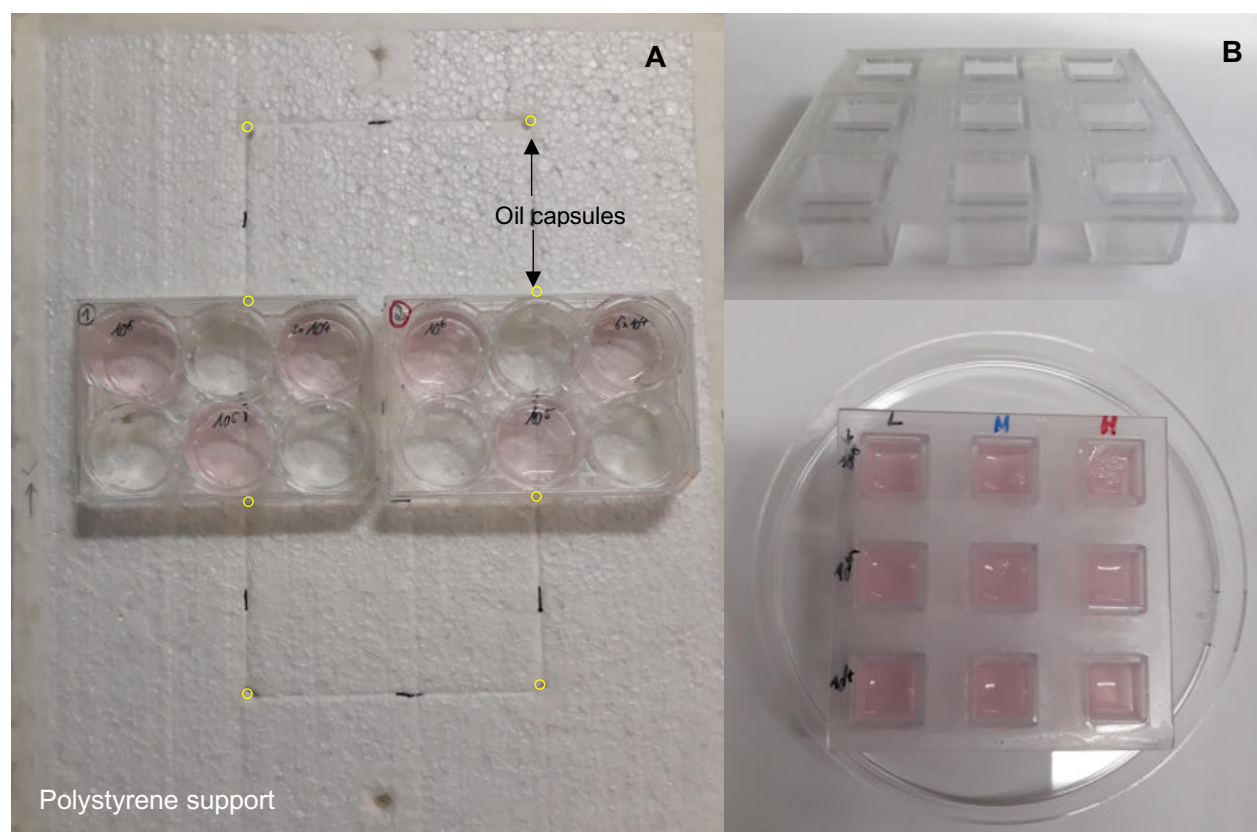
Set up for PET scanning: (A) Two 6-well plates were placed next to each other on a 1-cm thick polystyrene sheet containing 0.6-mm diameter spherical oil capsules visible on both the CT and MR images to enable CT-based attenuation correction of the PET data acquired on PET/MRI, (B) 3×3 cubic-well plate (5×5 cm, material: ClearVue™) containing nine 1 cm³ cubic wells with ⁸⁹Zr-labeled Jurkat cells suspended in Geltrex™ matrix. The 3D structure was placed into a petri dish before being supported on the 1 cm thick polystyrene sheet containing 0.6-mm diameter spherical oil capsules.
